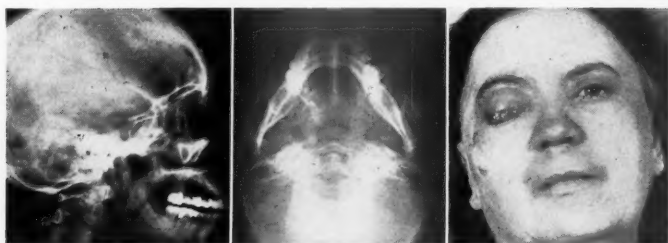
Roentgenograms of the skull and a photograph of Case 3 made before treatment. A squamous cell carcinoma, grade I, of the nasopharynx has destroyed both sphenoids and the lower portions of the posterior horns of the sella turcica and has entered the right orbit producing an exophthalmus.
